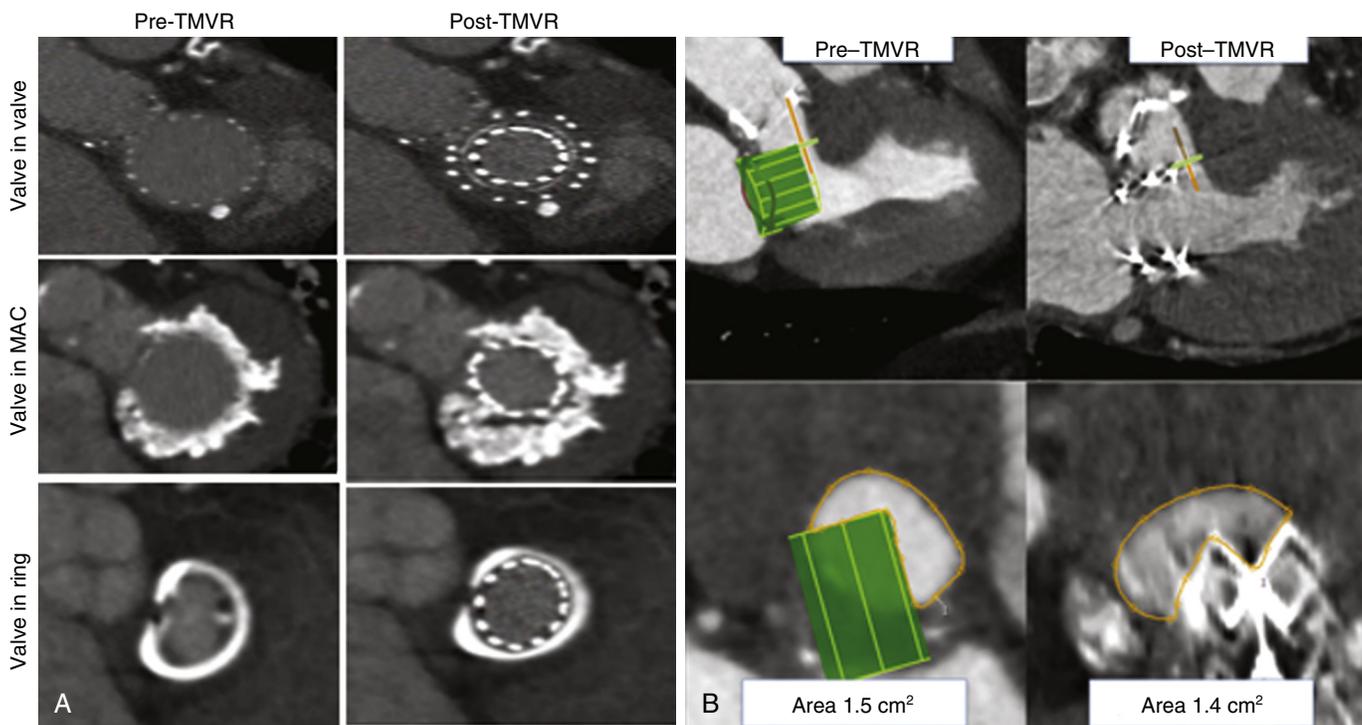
A, Pre- and post-transcatheter mitral valve replacement (TMVR) evaluation using cardiac computed tomography (CCT) for a valve-in-valve, valve-in-mitral angular calcification, and valve-in-ring scenarios. B, Pre-TMVR CCT in a valve-in-valve case projected a neo-left ventricular outflow tract (LVOT) area of 1.5 m². Post-TMVR CCT demonstrated a neo-LVOT area of 1.4 cm². (A, From Ge Y, et al. Role of cardiac CT in pre-procedure planning for transcatheter mitral valve replacement. JACC Cardiovasc Imaging 2021 [online ahead of print]. doi:10.1016/j.jcmg.2020.12.018)
